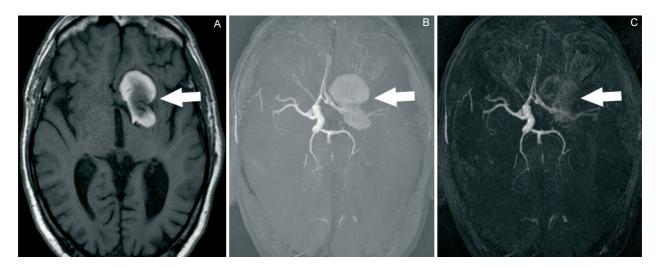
Left middle cerebral artery partially thrombosed giant aneurysm (arrow). The clotted blood shows in T1-weighted image (A) hyperintense signal and then, likewise to the figure 4 haematoma, conventional MRA image (B) is disturbed by extracellular methemoglobin, while subtractive MRA image (C) not.
